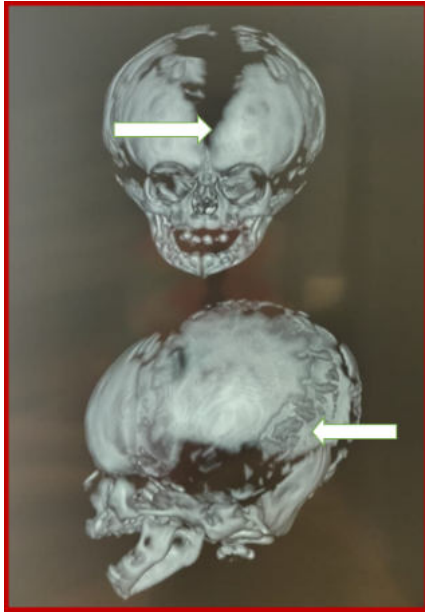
3D CT Scan Of Skull Shows Wide Open Anterior Fontanelle With Wormian Bones In Sutures.
